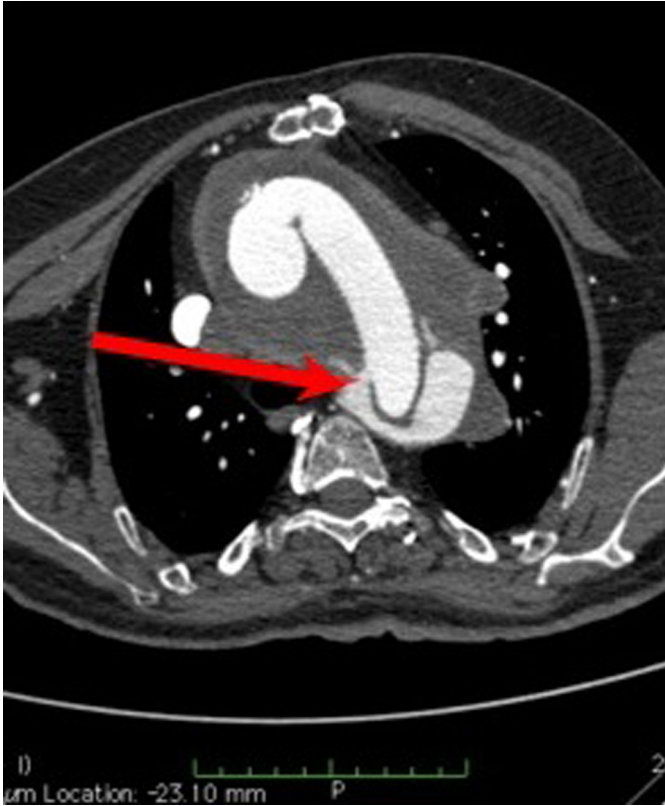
CT shows the periprosthetic fistula, as indicated by the red arrow.
